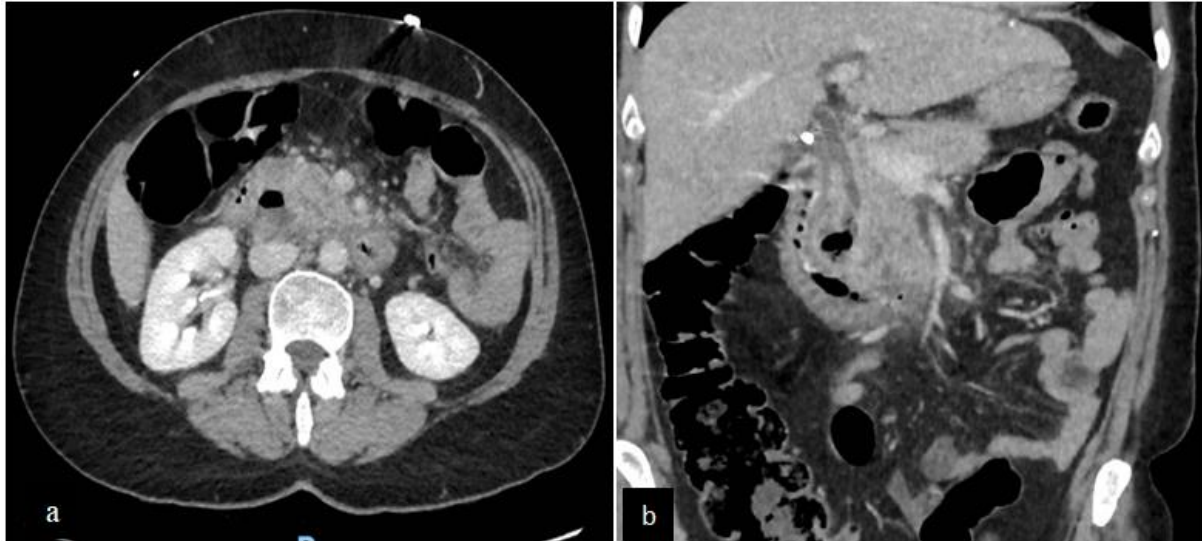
a) CT scan of mild cephalic interstitial pancreatitis (CTI SI = 2). The duodenum is oedematous due to contiguity with a duodenal diverticulum; b) dilated main bile duct upstream of a duodenal diverticulum with no sign of diverticulitis
